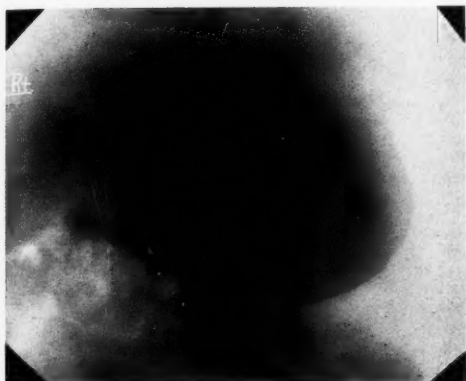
Appearance of the stomach four years after beginning the X-ray treatment.
